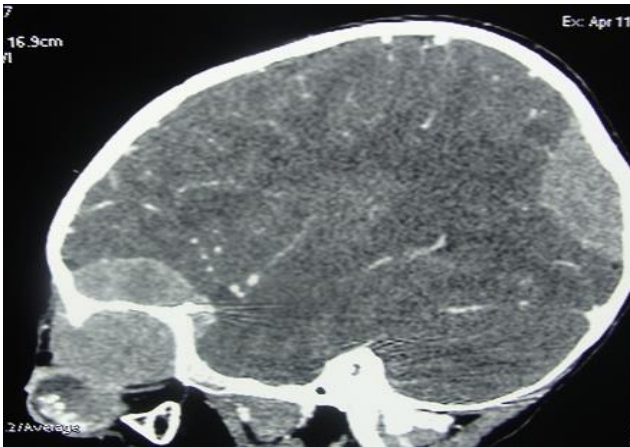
CT Scan (sagittal view) showing intracranial extension & metastasis of left eye retinoblastoma.
